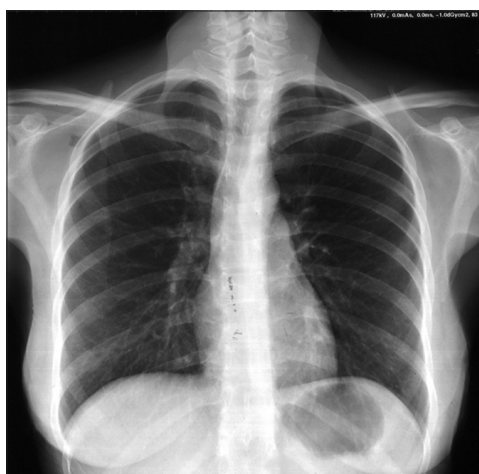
X-ray after bilateral thorax drainage positioning
